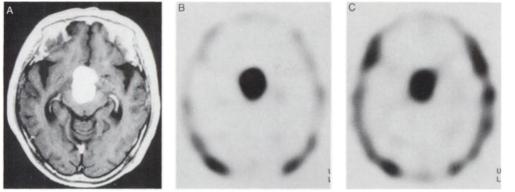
Transitional meningioma. (A) Postcontrast T1-weighted MR image shows a tumor in the suprasellar region. Thallium-201 SPECT early image (B) shows high uptake in the tumor, and the delayed image (C) shows relative retention.
